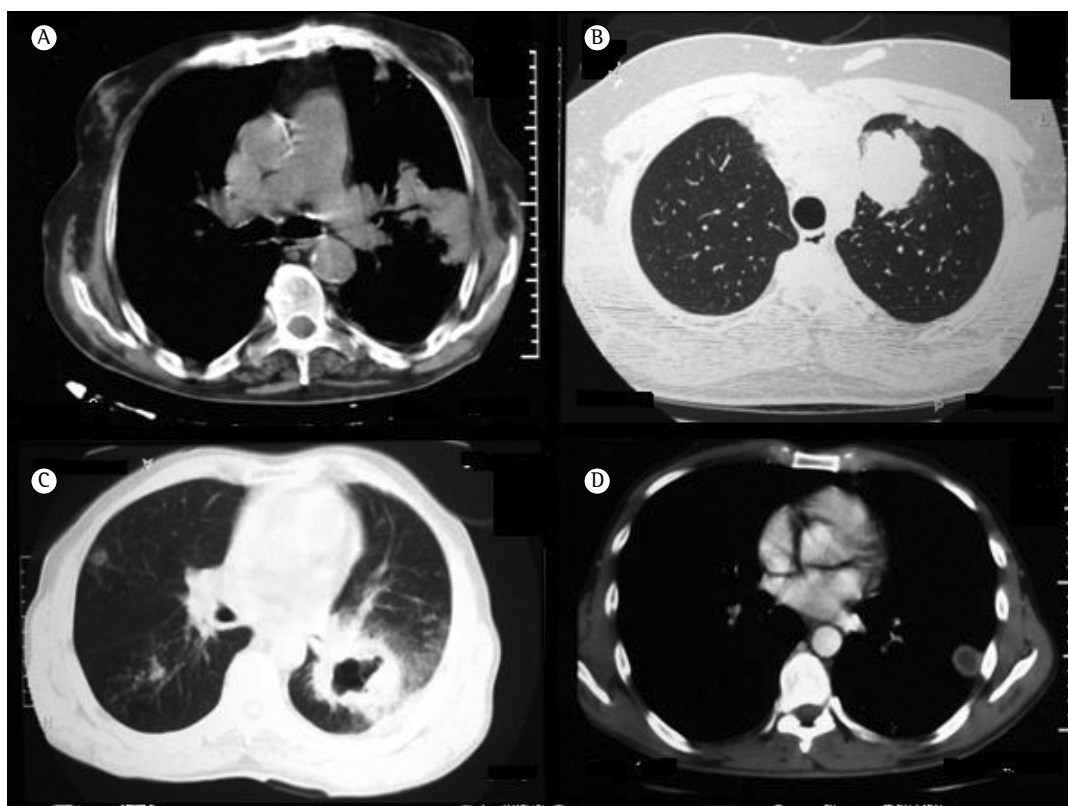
Helical CT scans showing an irregular lung mass (in A; male patient, 77 years old), a bosselated lung mass (in B; male patient, 30 years old), a spiculated lung mass (in C; male patient, 64 years old), and a regular lung mass (in D; male patient, 36 years old).
